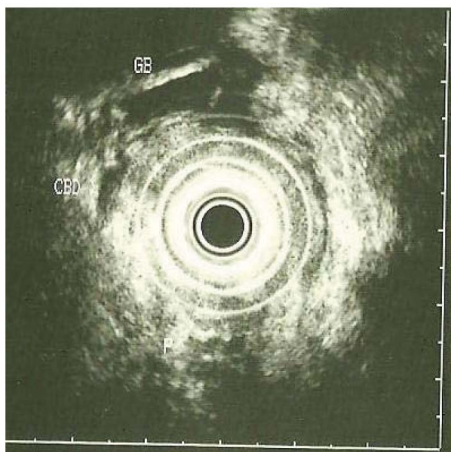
Endoscopic ultrasound
